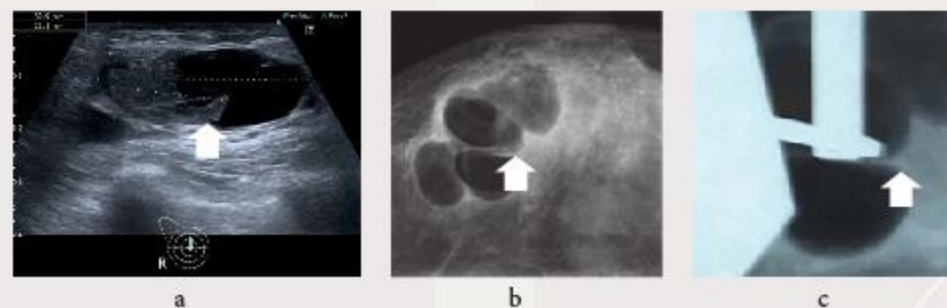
The use of X-ray signs of the CBC - thick walls and septations (arrows) for sCNB navigation
